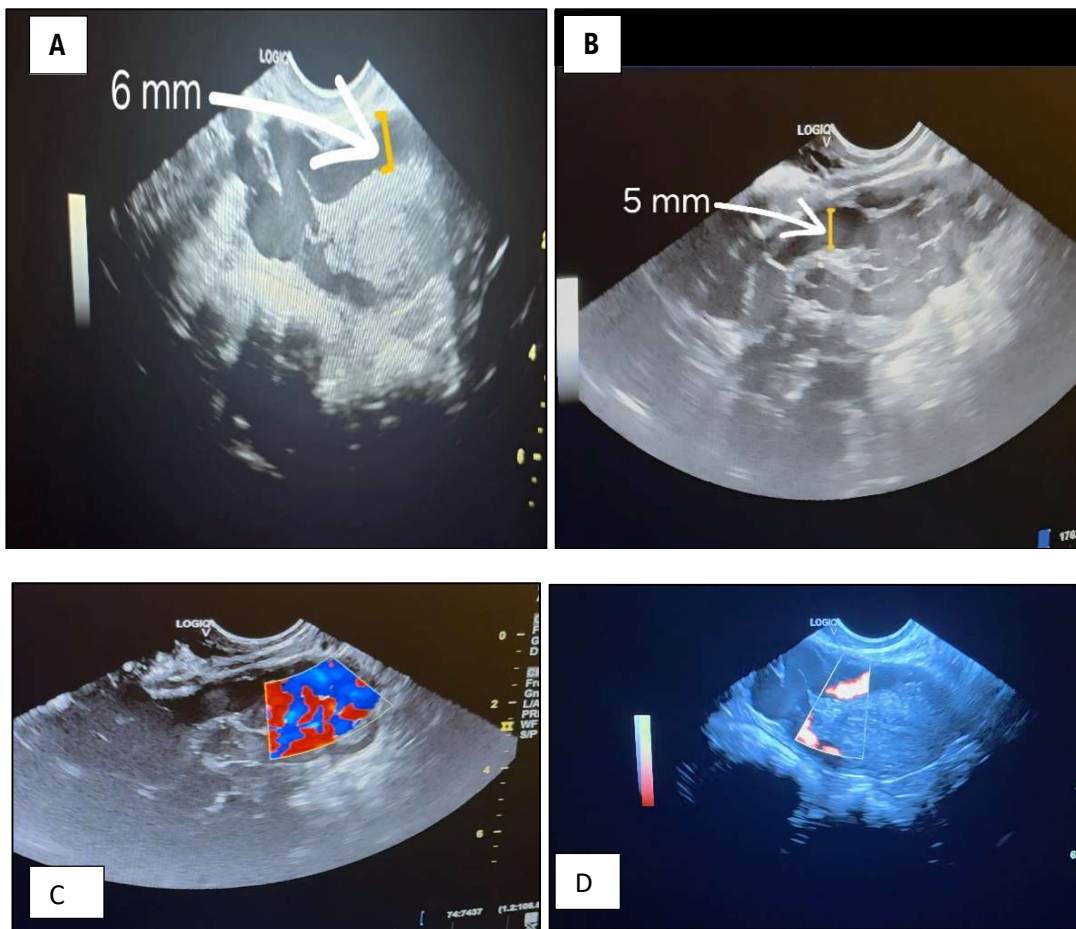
USG finding showing [A]enhanced myometrial vascularity of diameter 6mm,[B] multiple dilated vascular channels in both adnexa (5 mm diameter) and,[C],[D] increase perimetrial and myometrial vascularity on doppler and pulsed doppler respectively
